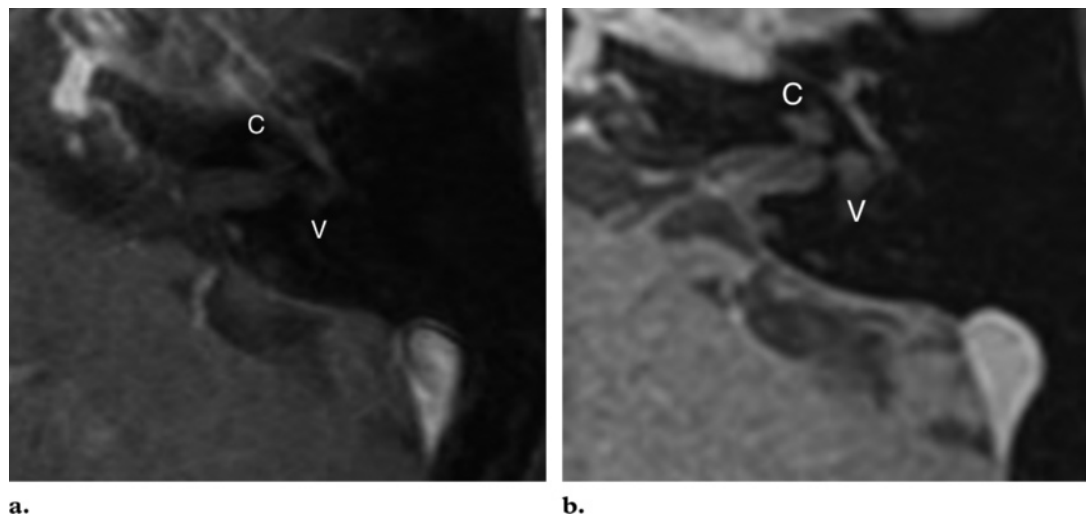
(a) Standard axial fat-suppressed T1-weighted MR image does not clearly depict the cochlea (C) and vestibule (V). (b) On an axial contrast material-enhanced image (volumetric interpolated breath-hold examination), the resolution of the cochlea (C) and vestibule (V) has improved dramatically.
